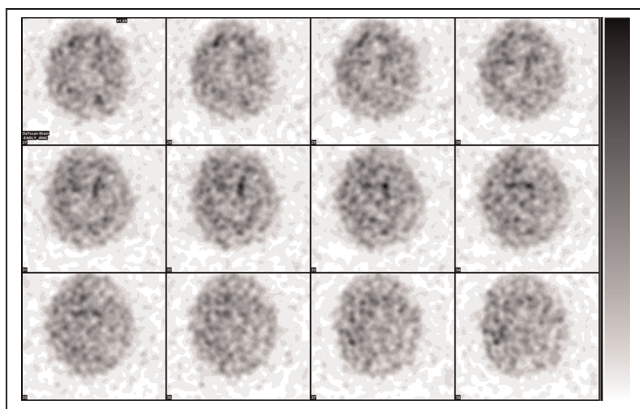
Axial brain SPECT images of 76-y-old man on pramipexole with history of resting and action tremors and cogwheel rigidity for 5 y. Images show decreased uptake bilaterally in putamen and right caudate nucleus, with loss of normal comma shape on right and scintigraphic evidence of probable presynaptic-deficit parkinsonian syndrome. Study was limited because of patient's body habitus and inability to perform SPECT rotation closer to patient's head with required diameter of 11–15 cm.
